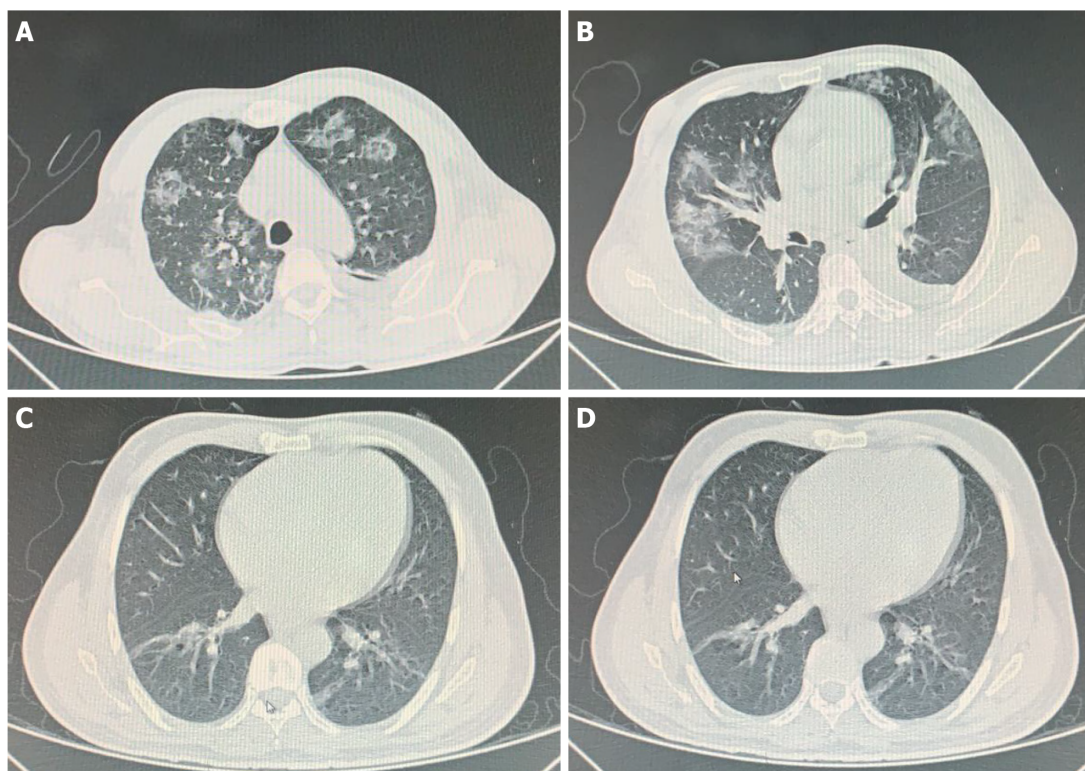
Chest computed tomography of transplanted patients with coronavirus disease 2019. A and B: Case 1, the lungs show reduced volume, left pleural effusion, atelectasis of the adjacent parenchyma and multiple diffuse ground-glass opacities; C and D: Case 2, discrete foci of ground glass attenuation affecting the bases of the lungs and discrete bilateral parenchymal bands.
